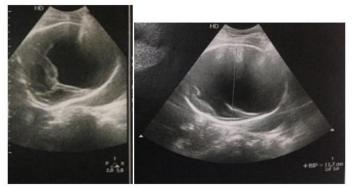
ultrasound images showing a single cerebral ventricular cavity filling the whole cranial box with a laminated parenchyma associated with thalamus fusion, measuring the biparietal diameter at 11.7 cm
